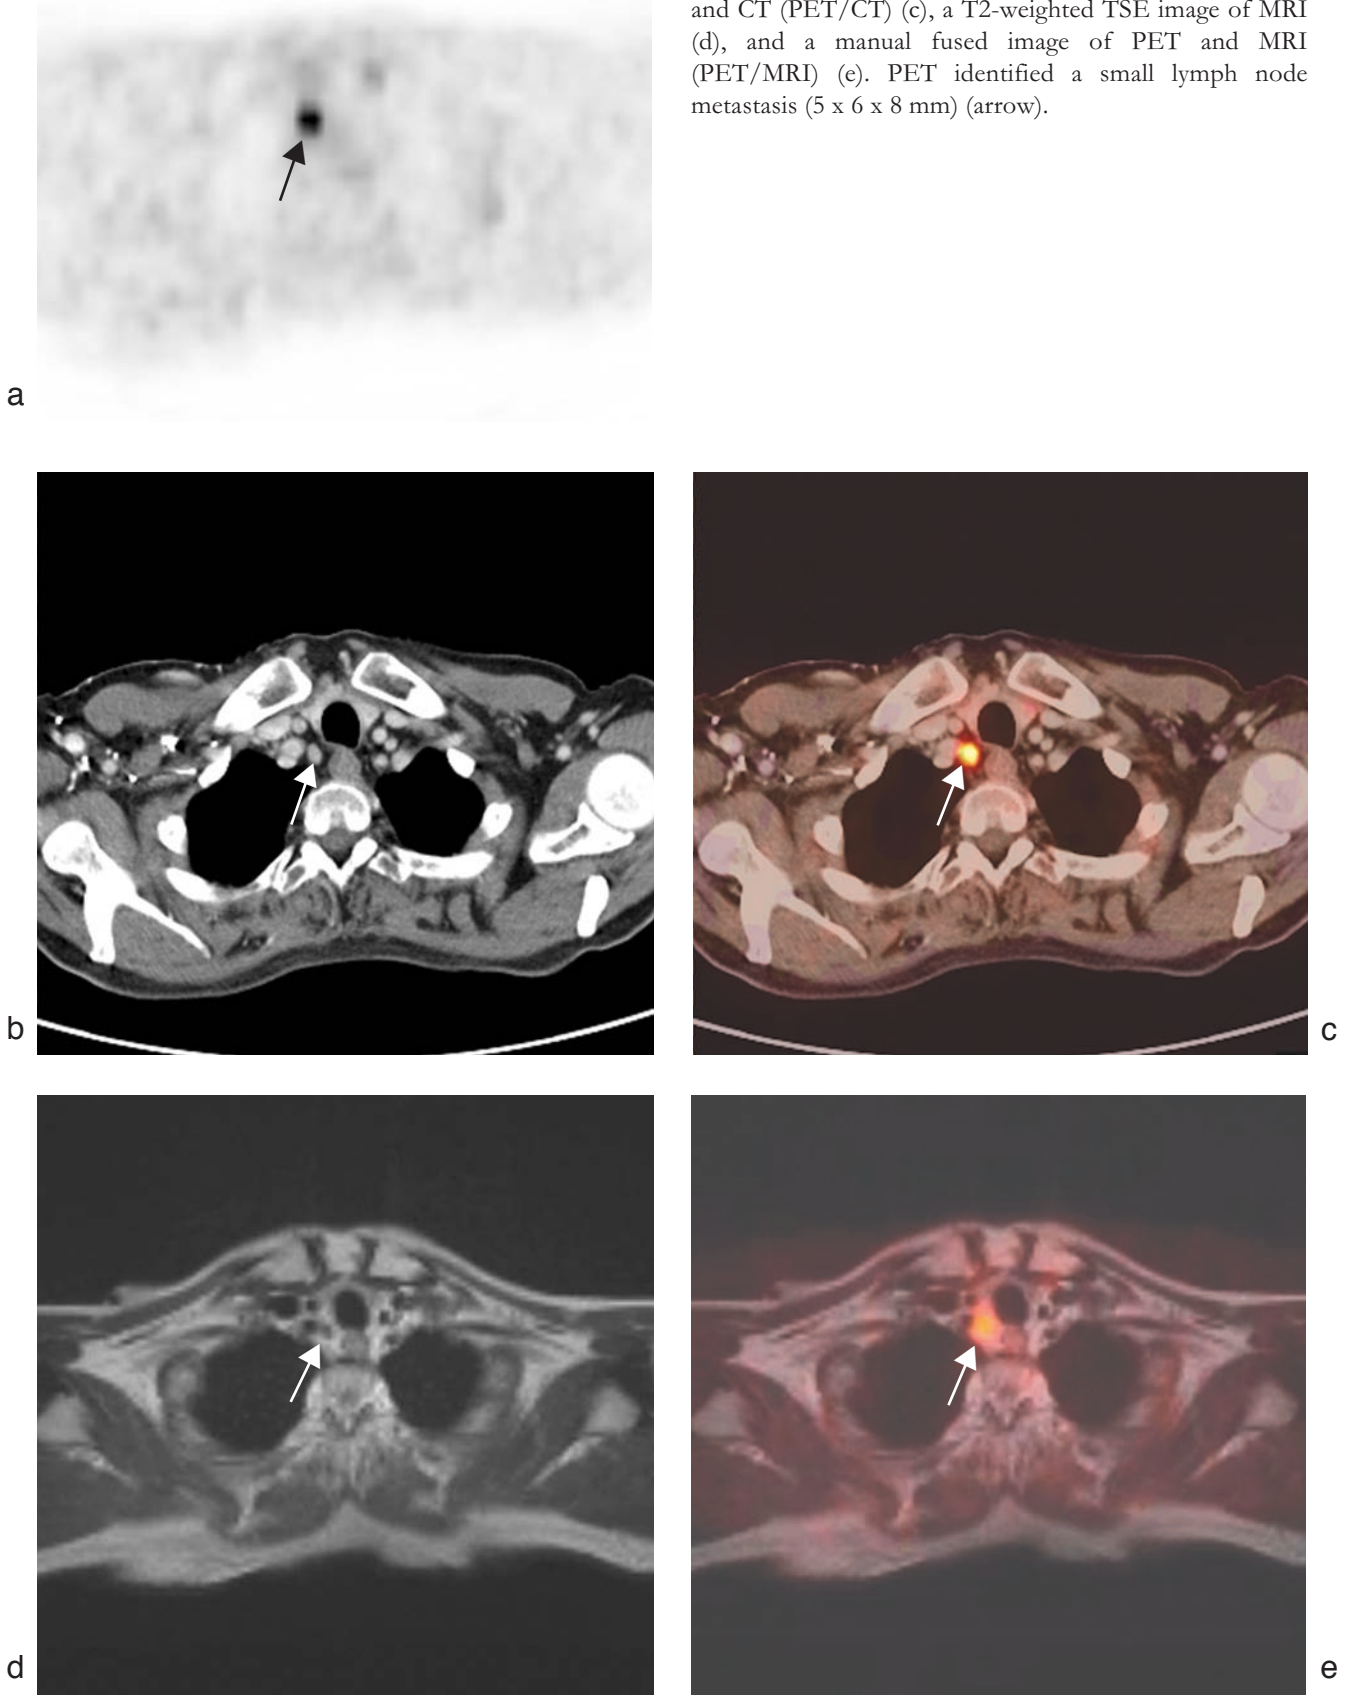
62-year-old male patient with an extensive metastatic disease of an intestinal carcinoid tumor. Corresponding axial view from the inlet of the thorax showing a [¹⁸F]FP-Gluc-TOCA PET image (a), a venous-dominant contrast-enhanced CT image (b), an automatic fused image of PET and CT (PET/CT) (c), a T2-weighted TSE image of MRI (d), and a manual fused image of PET and MRI (PET/MRI) (e). PET identified a small lymph node metastasis (5 x 6 x 8 mm) (arrow).
